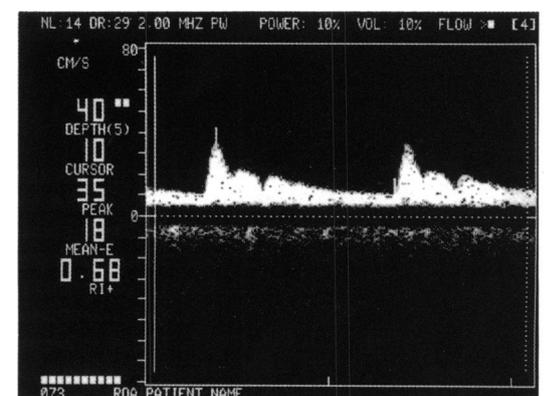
A videographic print-out of a pulsed Doppler ultrasound (2 MHz) of the ophthalmic artery is shown. The numbers on the left show from the top the gated depth in mm the diastolic velocity in cm/s, the peak velocity in cm/s and the mean enveloped velocity in cm/s. The lowest figure is the calculated resistivity index as outlined in the text.
